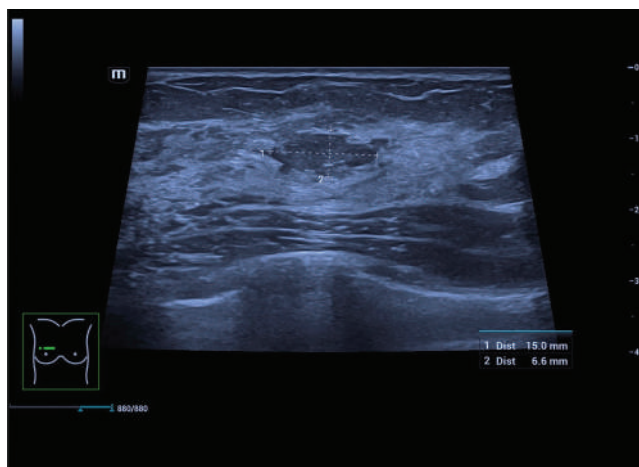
Ultrasonographic image of the right breast showing an isoechoic solid lesion measuring 15×7×18 mm, located 3 cm from the nipple at the 11 o'clock position, with its long axis parallel to the skin, focal contour irregularities, microlobulations, and no vascular signal on color Doppler imaging.
